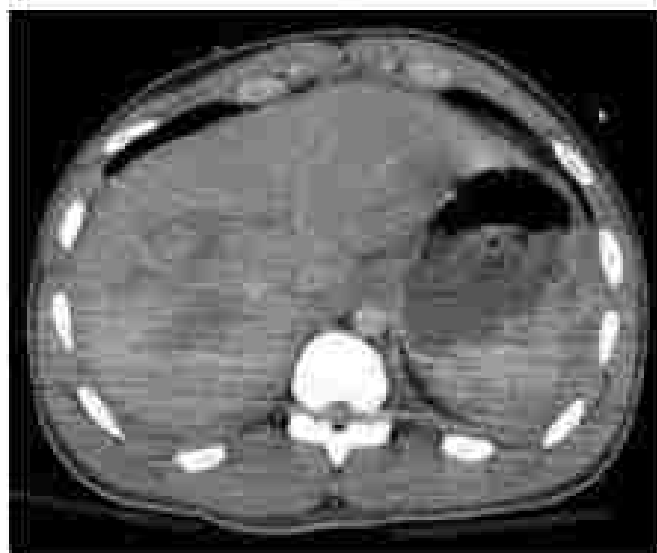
Abdominal computed tomography scan in a patient with grade III blunt cardiac injury showed a grade III liver injury and a grade II splenic injury but no obvious reason for the patient's hypotension.
